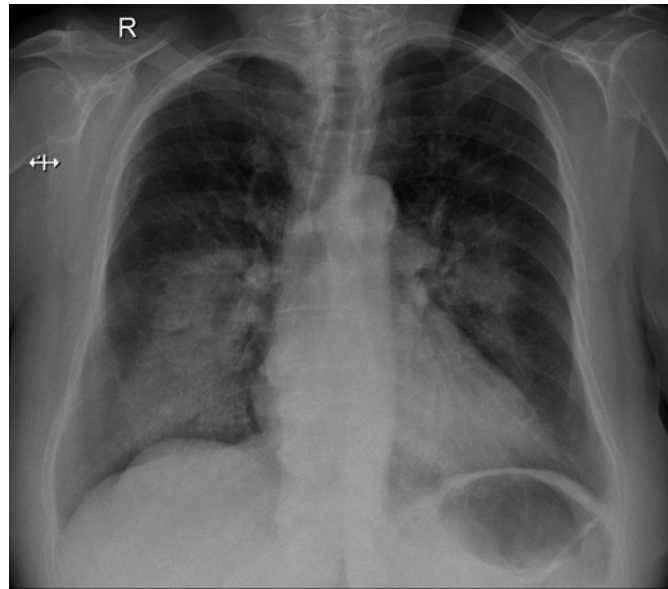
The patient's chest radiograph when admitted to the emergency department.
